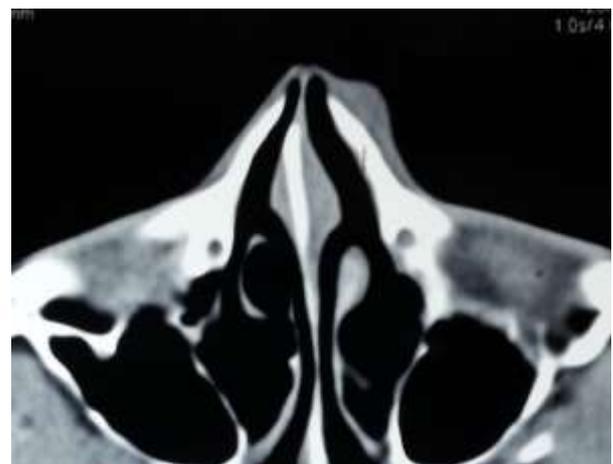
An axial CT scan image showing a homogenous mass over the left nasal bone. There is no evidence of bone erosion.
